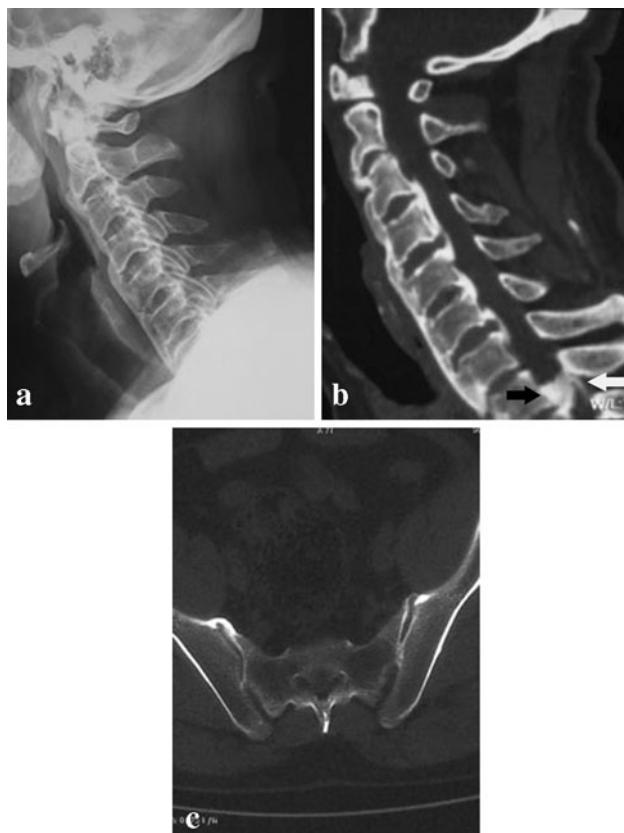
X-ray and CT scan documented OALL at C2–C7, OPLL at C3–C7 and T1–2, and OLF at T1–2. a OALL at C2–C7, b OPLL (black arrow) and OLF (white arrow) at T1–2, c no sacroiliac erosion
